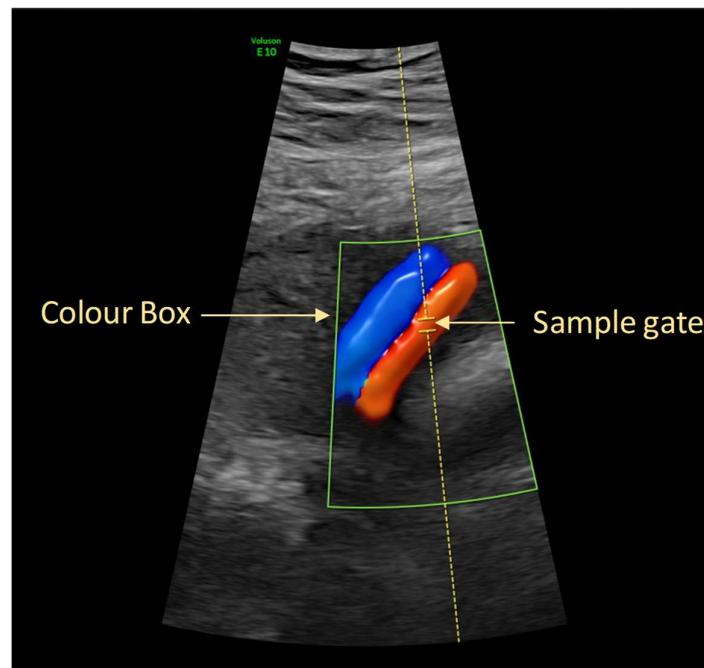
Colour flow mapping and positioning of pulsed Doppler sample gate with contemporary ultrasound equipment. The user defined colour box allows superimposition of colour coded Doppler signals over the grey scale image. The colour denotes the direction of Doppler shift relative to the transducer; red is generally toward the transducer and blue is away. This enables the user to accurately define the area for analysis of received echoes by placement of the sample gate. Image produced by D Paoletti.
